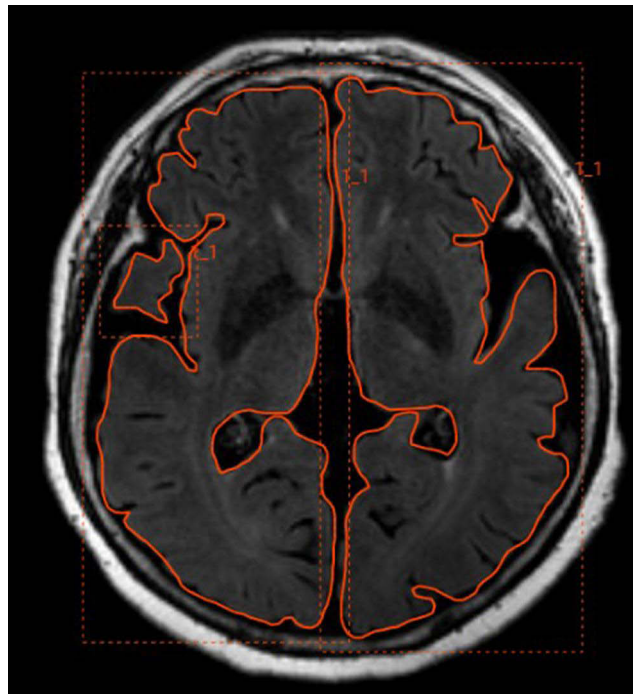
The ROIs on T1WI MRI images.
